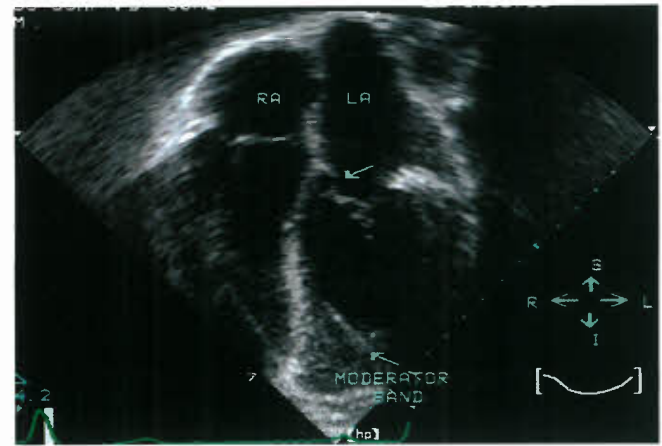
Apical four-chamber view in a patient with ventricular inversion with congenitally corrected transposition of the great vessels {S, L, L}. The left-sided atrioventricular valve has attachments to the ventricular septum, whereas the right-sided valve does not, allowing diagnosis of a left-sided tricuspid valve and a right-sided mitral valve. In addition, the septal hinge point of the tricuspid valve is inferior to that of the mitral valve, which is another distinguishing feature of a tricuspid valve. There is a moderator band near the apex of the left-sided ventricle, further defining this ventricle as a morphologic right ventricle. I, inferior; LA, left atrium; RA, right atrium; S, superior.
